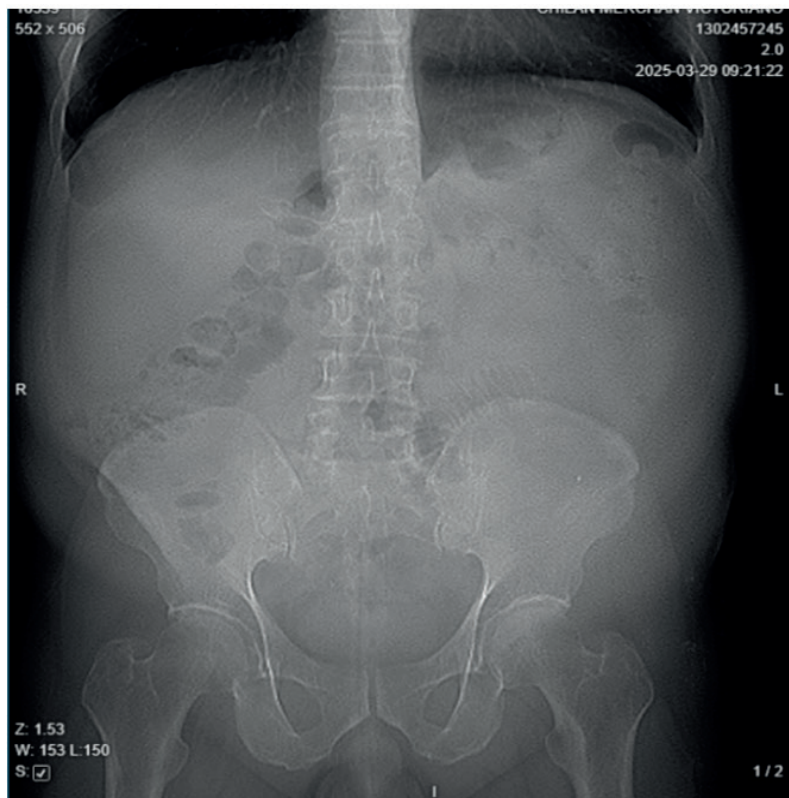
Abdominal X-ray in standing position showing thickened walls in the sigmoid colon.
